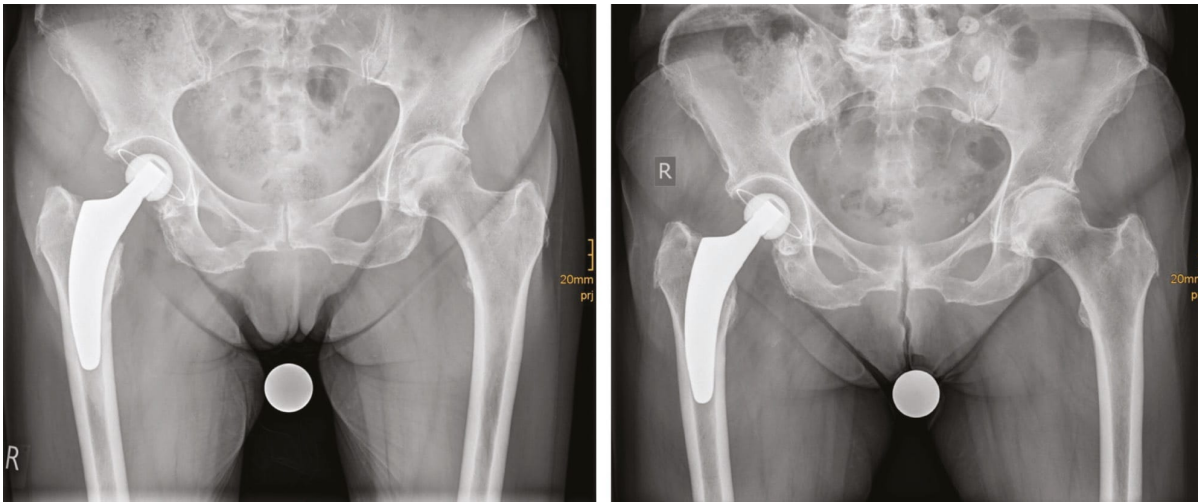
post-Op X-ray with cementless optimys short stem and cementless RM-Vitamys (Mathys) and FU after 2 years. Harris hip score 100 and Oxford-12 hip score 48. Normal leg length and restoration of the hip center.
